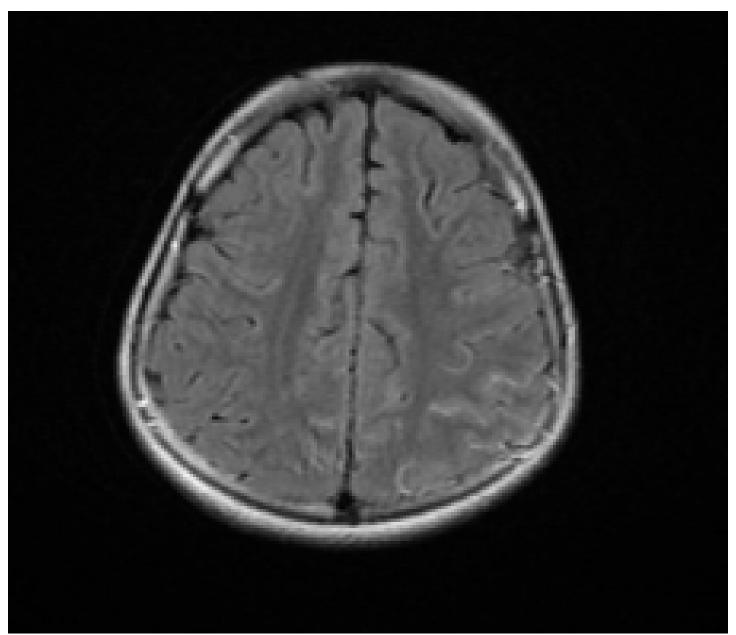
Brain MRI, axial FLAIR, from readmission to inpatient unit, showing worsening signal enhancement of the cerebral sulci.
